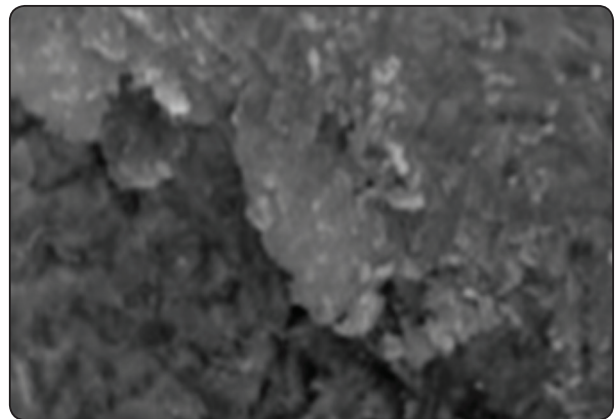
SEM of CT zirconia showing resin cement covering the surface
